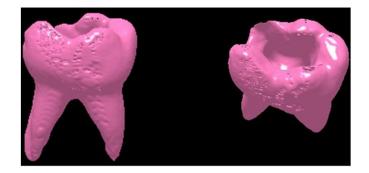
Three-dimensional modeling of the image obtained as a result of scanning with cone-beam computed tomography after caries removal and access cavity preparation.
